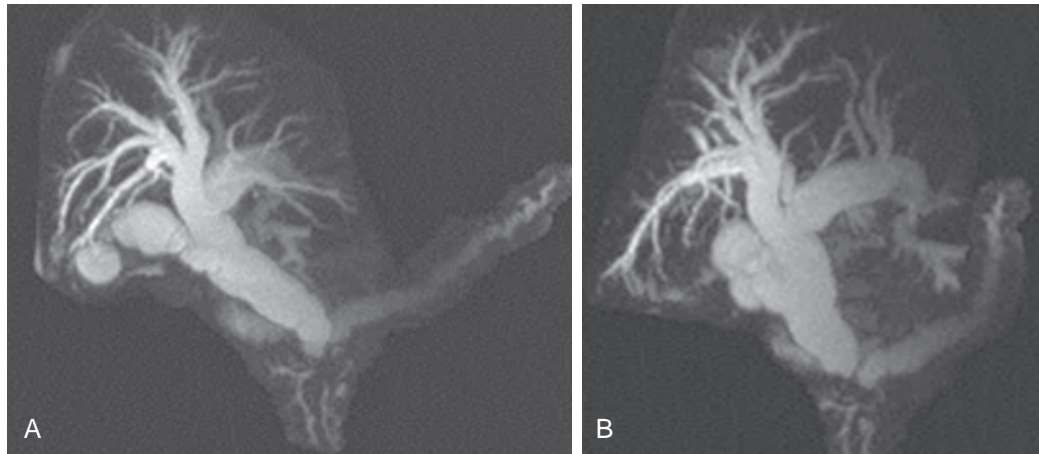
MR cholangiogram: enhanced three-dimensional technique. A. Three-dimensional MIP image from T2-weighted MRCP in a patient with obstruction and dilated ducts from pancreatic carcinoma better demonstrating detail of the dilated bile ducts. B. Slightly rotated view demonstrates distal bile duct and pancreatic duct junction to better advantage.
